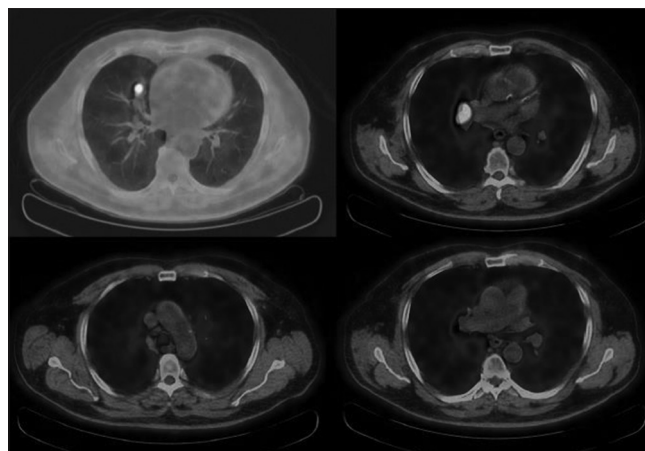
Refractory hyponatremia was observed in a patient; computed tomography and positron emission tomography-computed tomography revealed a metabolically active tumor of 2.8 cm in the middle lobe, while enlarged lymph nodes at stations 11R and 4R were found on computed tomography. Positron emission tomography-computed tomography was confirmed at station 11R alongside the tumor. “No fluoro-2-deoxy-D-glucose-accumulation was found in stations 4R and 7, but endobronchial ultrasound and endoscopic ultrasound were positive for malignancy in stations 11R, 4R, and 7.” The tumor, node, and metastasis classification based on computed tomography and positron emission tomography-computed tomography was T1bN1M0; thus, it was modified to T1bN2M0 following endobronchial ultrasound and endoscopic ultrasound. Considering the treatment was changed from primary surgery to curative-intent chemotherapy and radiotherapy, the clinical implications herein are profound
